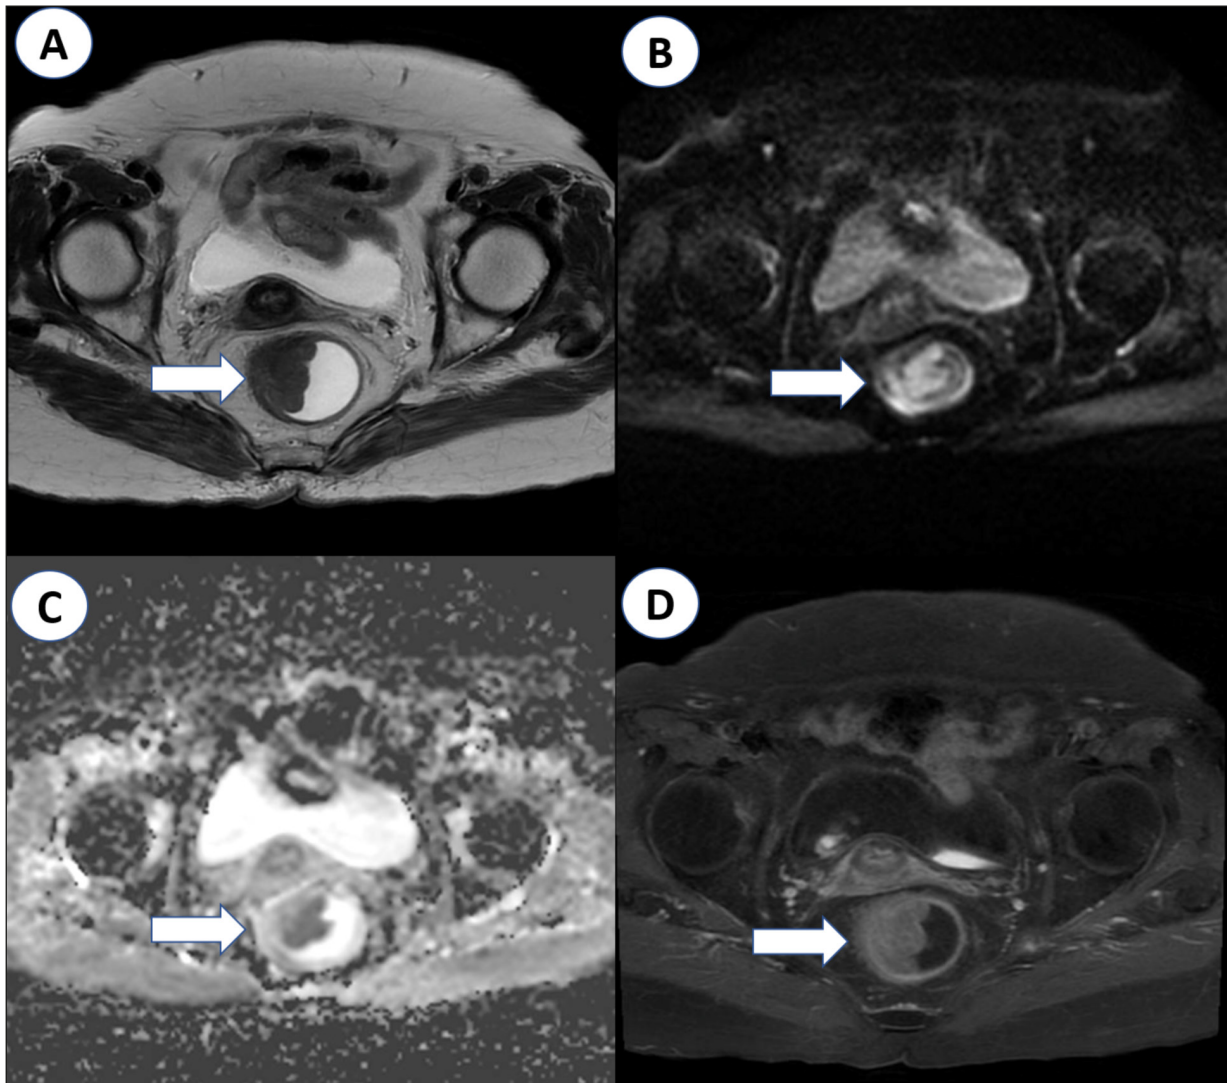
Pelvic magnetic resonance imaging to assess tumor (arrow) staging before treatment. A, Axial T2-weighted image. B, Axial diffusion-weighted image. C, Axial apparent diffusion coefficient map. D, Axial T1-weighted image with contrast agent.
